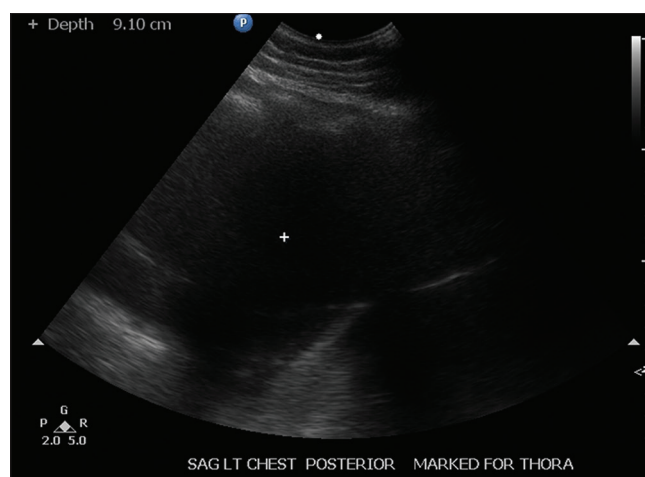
Ultrasound image of the thorax depicting the left sided pleural effusion
